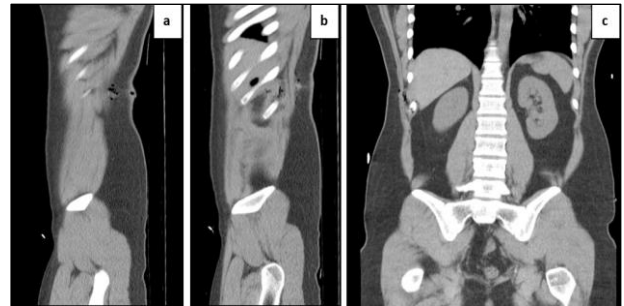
(a, b, c) Stab wound right flank with no peritoneal disruption: CT sagittal and coronal of knife wound track with discontinuous foci of gas used to identify a knife track.
